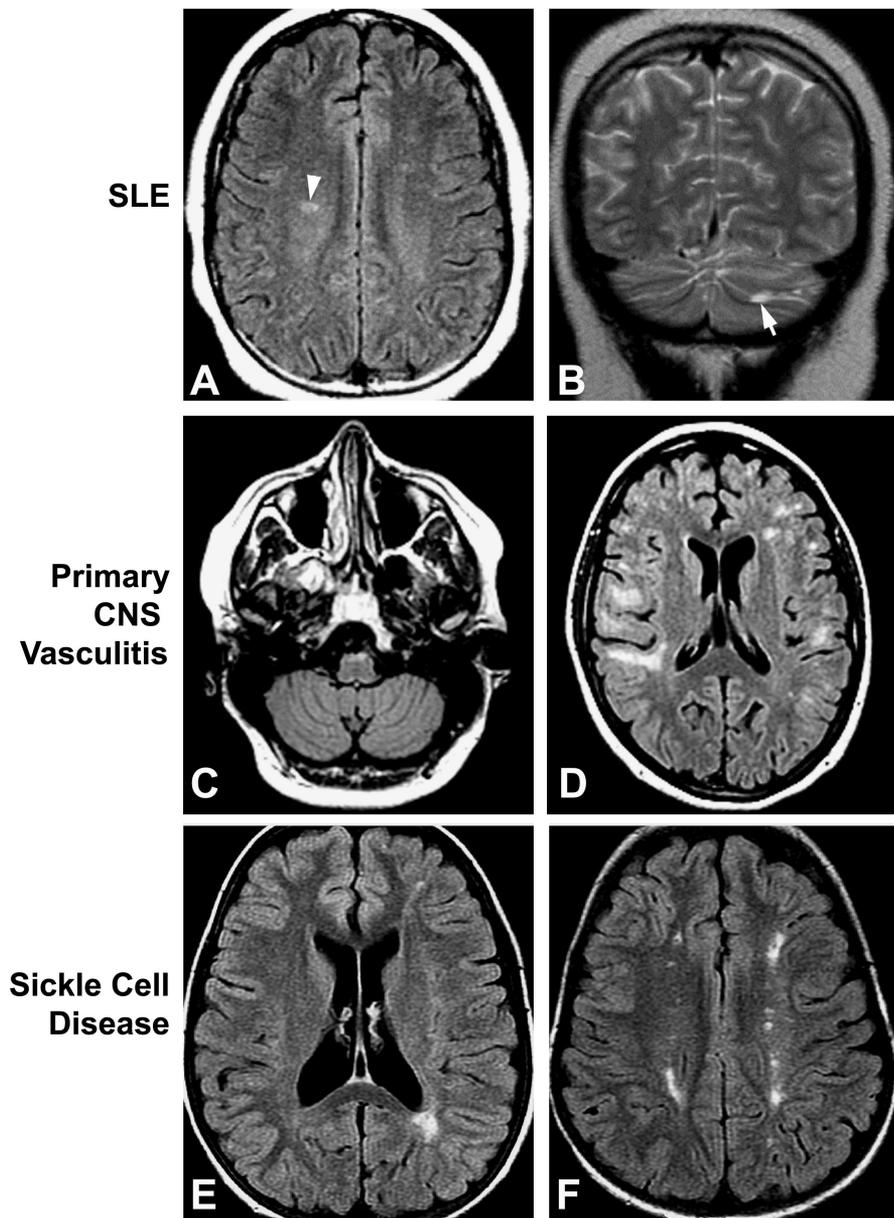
Differential diagnoses of white matter lesions: ischemic etiologies. (A, B) Axial fluid-attenuated inversion recovery (FLAIR) and coronal T2 images of a child with CNS vasculitis associated with systemic lupus erythematosus (SLE). Small punctate white matter lesions are noted in the right centrum semiovale (arrowhead) and in the left cerebellar hemisphere (arrow). There are no periventricular white matter lesions or involvement of the corpus callosum, as would be expected in a child with multiple sclerosis (MS). MR angiography demonstrated vascular beading and narrowing of the A1 segment of the anterior cerebral artery (not shown), findings not present in patients with MS. (C, D) Axial FLAIR images through the brainstem and the cerebral white matter show multiple foci of increased signal. The patient, a 16-year-old girl, presented with headache, optic neuritis, and fatigue. Systemic serum markers for vasculitis were negative. Brain biopsy confirmed primary CNS vasculitis. (E, F) Axial FLAIR images demonstrating periventricular and punctate deep white matter lesions in a patient with sickle cell disease. The MRI appearance is difficult to distinguish from MS, and delineation of the diagnosis requires careful clinical history of features compatible with sickle cell disease. MR angiogram in patients with sickle cell disease frequently demonstrates abnormal vasculature, which would not be present in MS.
